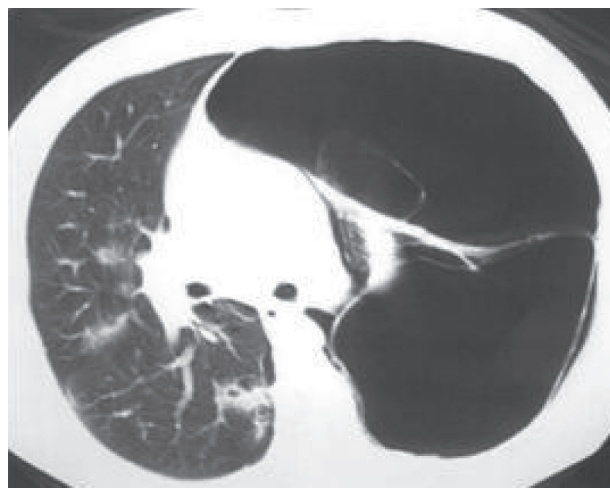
Computed Tomography thorax showing double wall sign with bulla.
